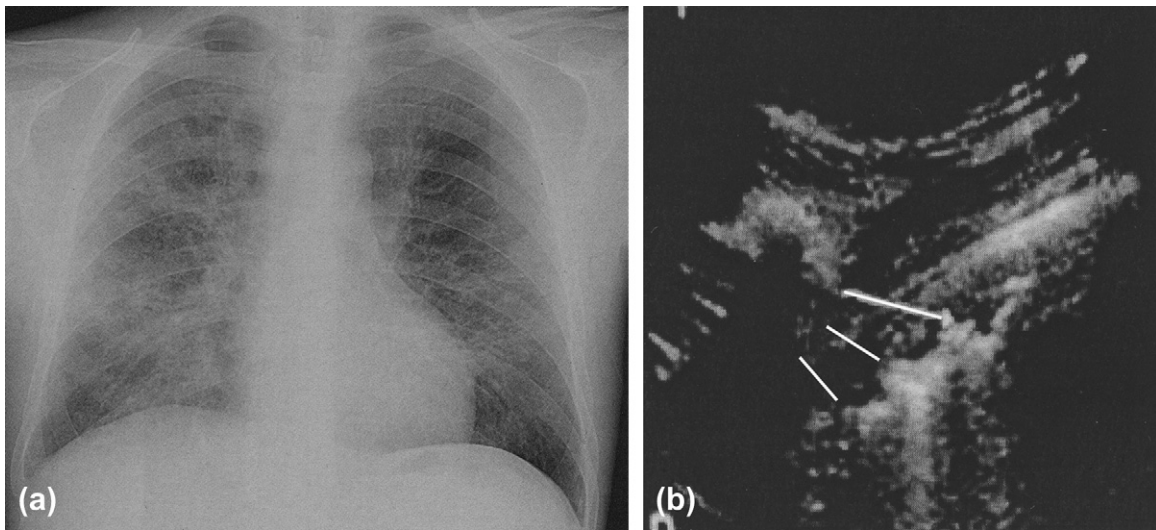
Interstitial pneumonia. (a) Plain film: interstitial pattern; and (b) US: ring-down artifact and pleural irregularity.
